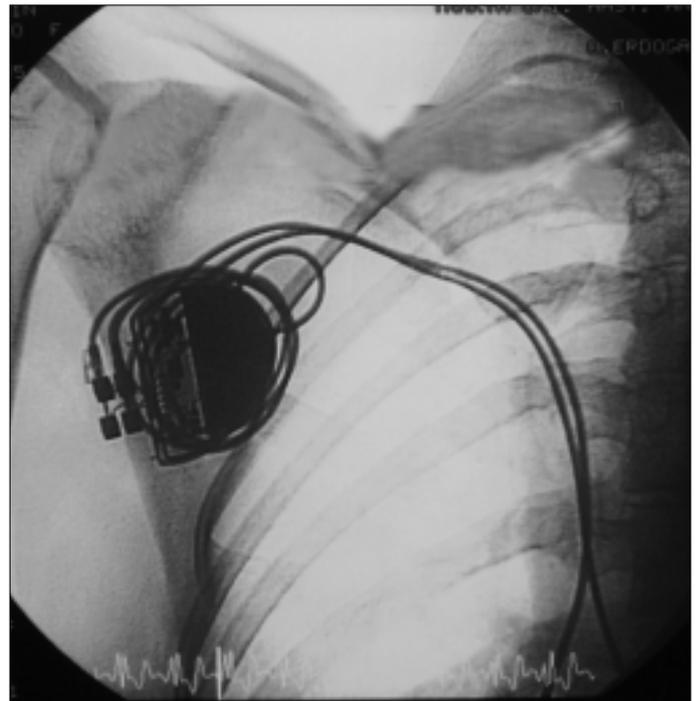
Chest X-ray showing lead damage and thinning at the medial sternoclavicular junction due to crush injury
